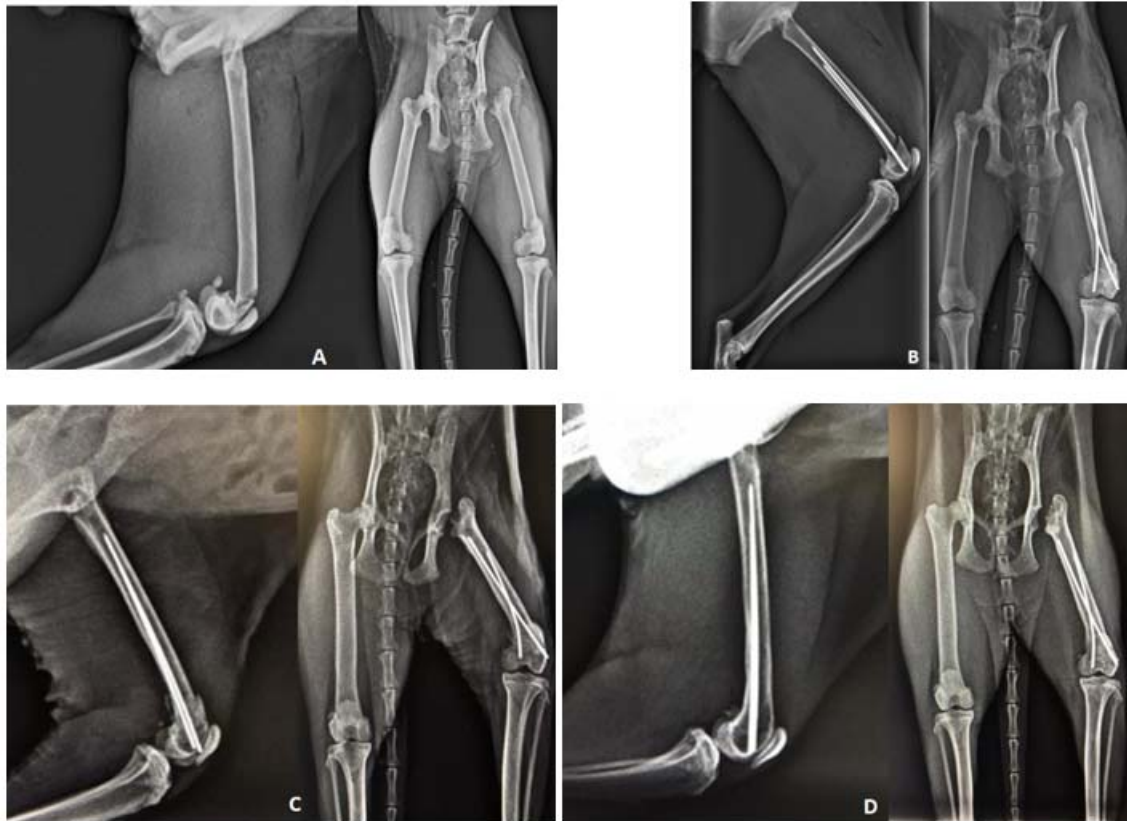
Craniocaudal and mediolateral radiographic views of femur fracture before (A), postoperatively (B), 2 weeks (C) and 2 months (D) after dynamic intramedullary cross pinning of femur fracture.
